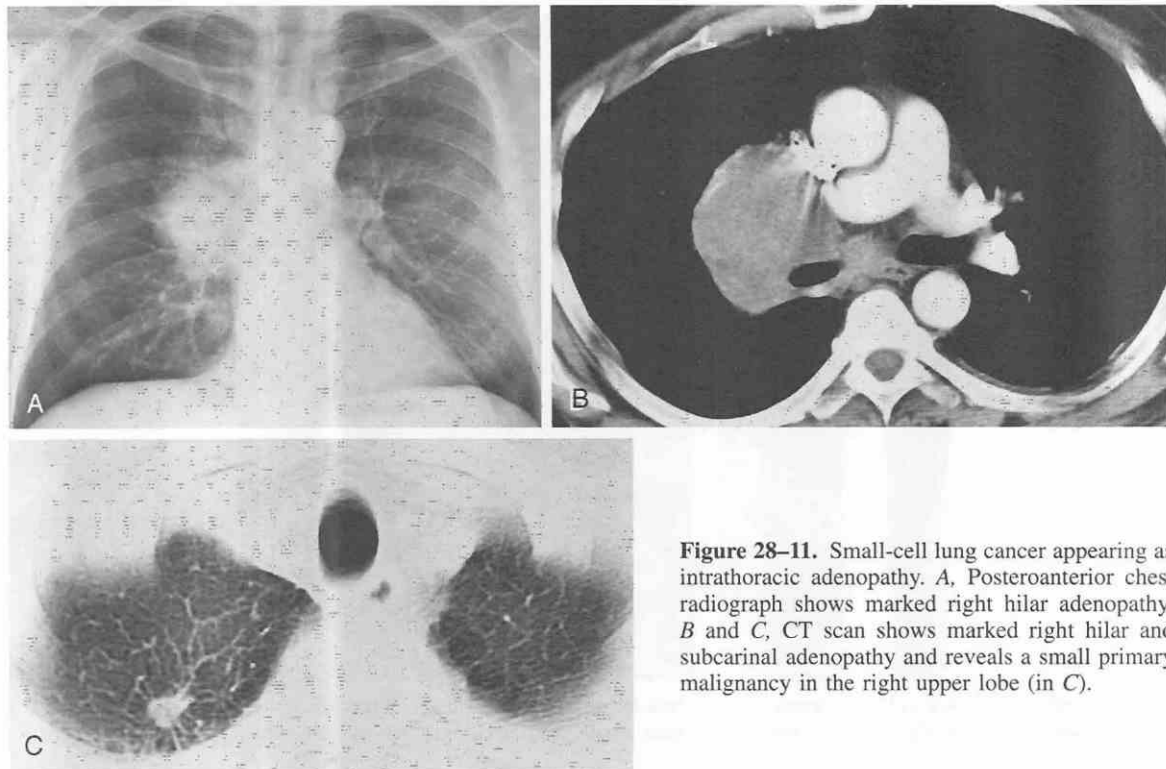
Small-cell lung cancer appearing as intrathoracic adenopathy. *A*, Posteroanterior chest radiograph shows marked right hilar adenopathy. *B* and *C*, CT scan shows marked right hilar and subcarinal adenopathy and reveals a small primary malignancy in the right upper lobe (in *C*).
